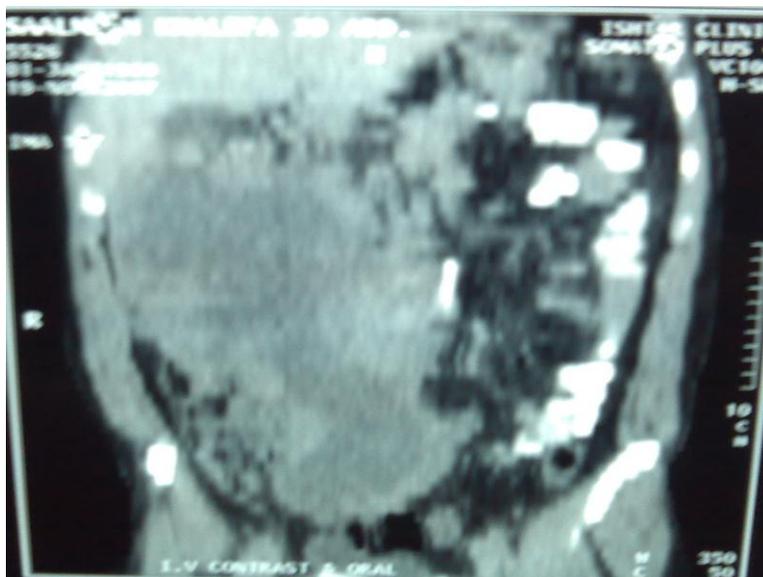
Coronal section of abdominal spiral CT scan revealed big mass almost occupy whole abdomen with central necrosis.
